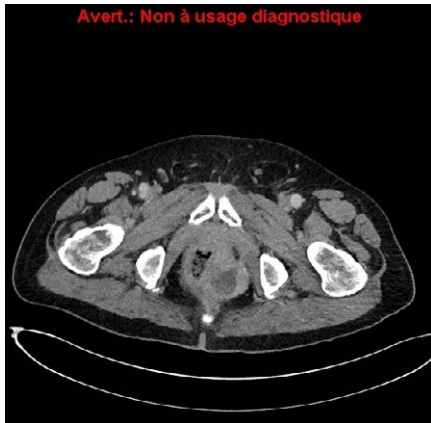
Computed Tomography scan showing a left lateral heterogeneous mass.
